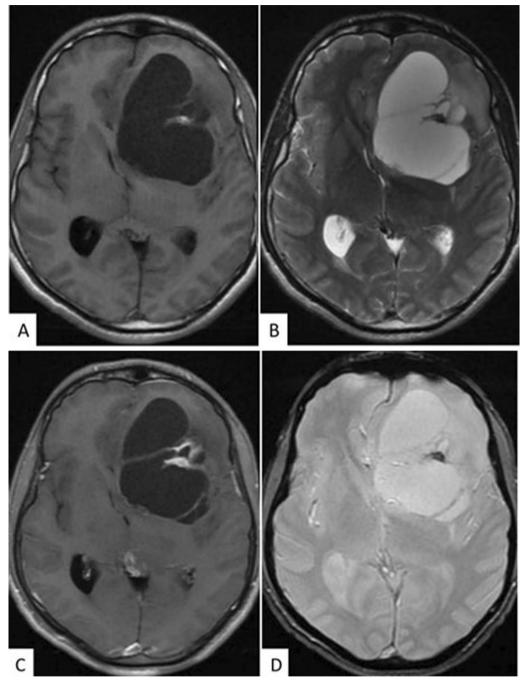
Preoperative axial brain T1Wl (A), and T2Wl B demonstrates an intra-axial multilocular cystic lesion with septations involving left frontal white matter, measuring approximately 73 × 52 mm in size. Post-contrast T1-weighted axial C cut shows eccentric focal multilocular pattern enhancement around the calcification. Gradient echo (GRE) sequence D confirms the eccentric low signal intensity of dense dystrophic calcification
